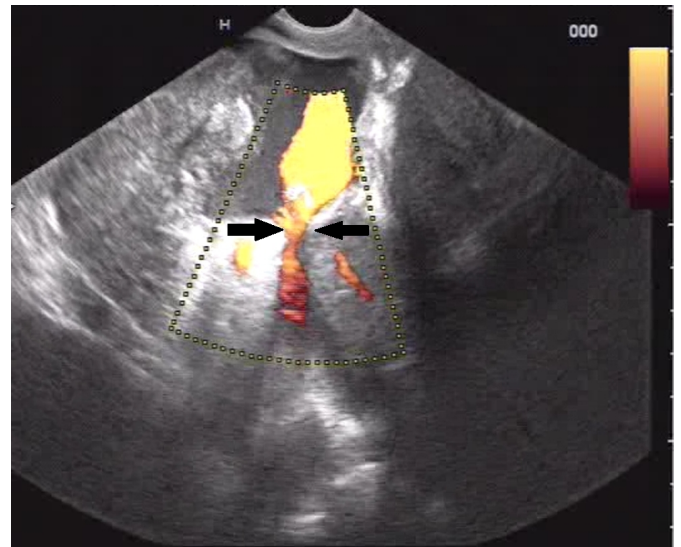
EUS: Power Doppler showing vascularity in collection. The blood can be seen leaking into collection (arrow).
